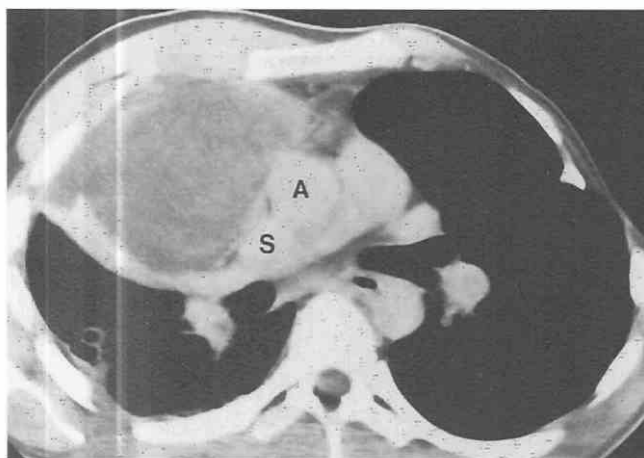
Nonseminomatous germ cell malignancy. CT shows large mixed-attenuation anterior mediastinal mass. Trans-thoracic needle aspiration biopsy revealed endodermal sinus tumor. The left pectoralis major muscle is absent, consistent with Poland syndrome. A, aorta; S, superior vena cava.
